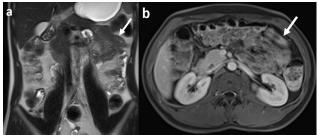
A 15-year-old boy with known Crohn's disease. Coronal HASTE image (a) and axial contrast-enhanced T1-weighted with fat suppression image (b) show wall thickening of the jejunal loops (arrows).
